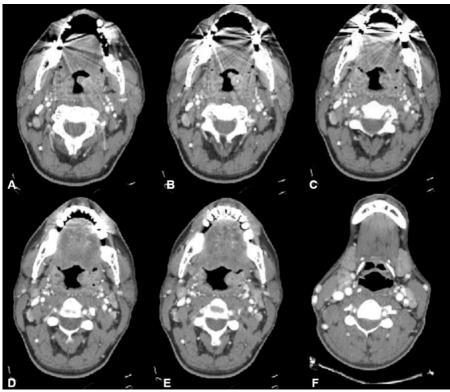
Superior to inferior axial sections of computed tomography of neck with contrast. Mild increased swelling of the left tonsil compared to the right (A - E). Similar heterogeneous appearance of both tonsils suggesting inflammation/microabscesses. No fluid collection amenable to drainage. Bilateral jugular chain lymphadenopathy (F).
